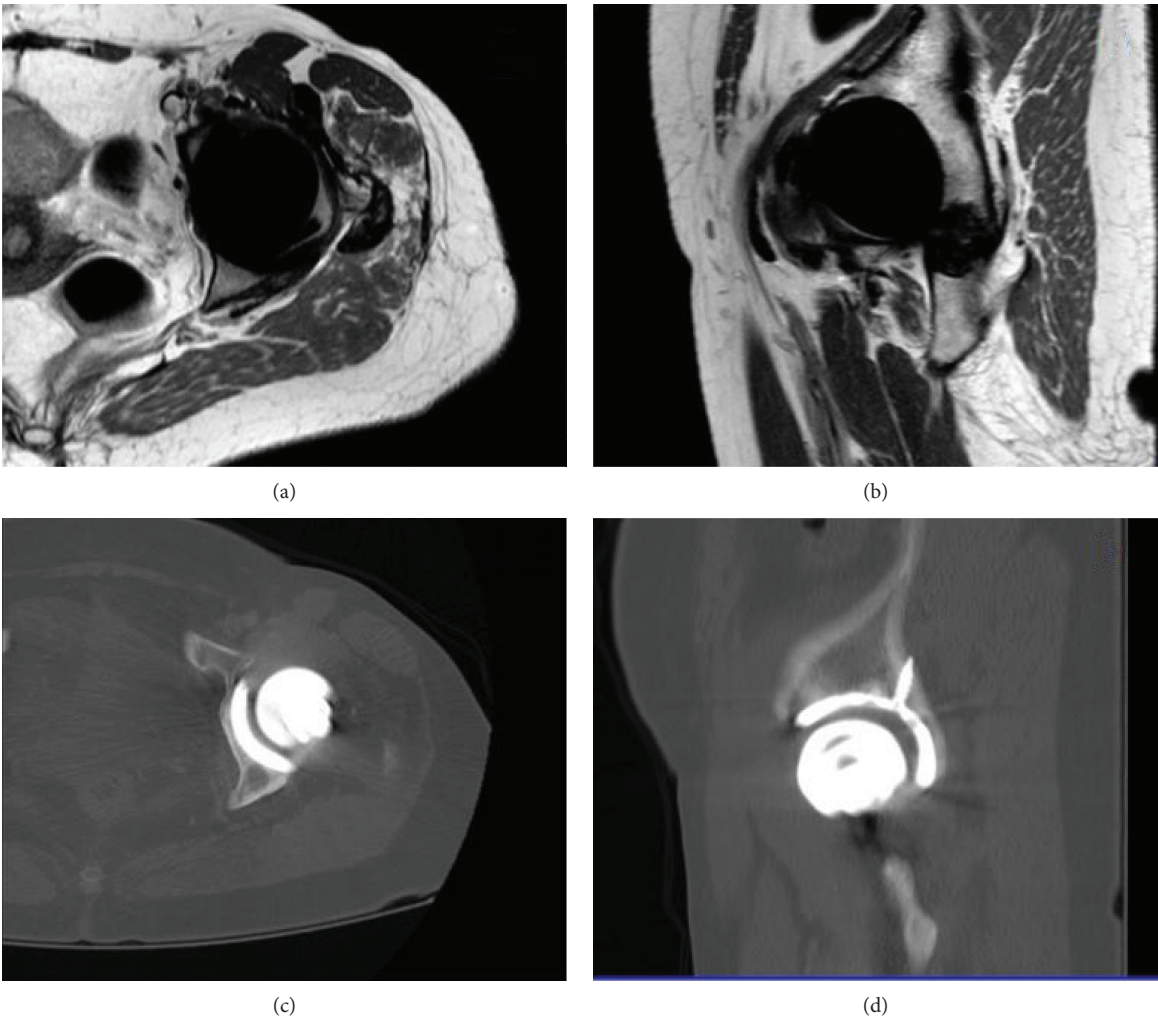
MRI (a) and (b) and CT (c) and (d) images taken five years post-RHA. There were no signs of pseudotumour after an extended follow-up.
